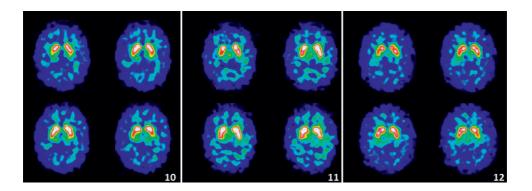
Three [123 I]FP-CIT SPECT scans of patients with normal scan analyses in the expert visual analysis but abnormal scans in the automated semi-quantitative BRASS analysis. The color scale indicates SBRs of striatal DAT binding and the scale bar previously presented in Figure 4.
